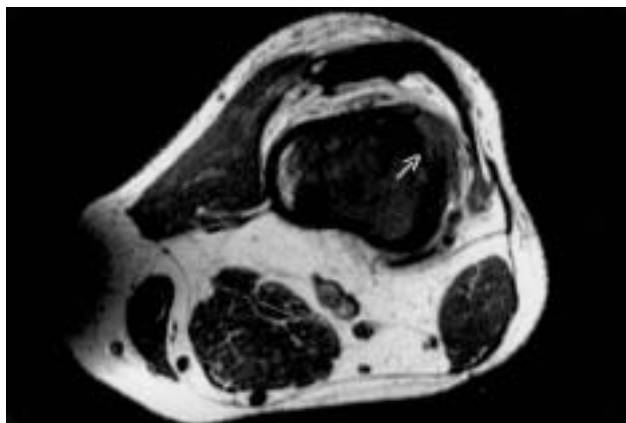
Leiomyosarcoma of the left knee in a 40-year-old male. Axial T1-weighted (550/20/2) spin-echo image shows cortical destruction at the anterior lateral distal femoral shaft (arrow).
